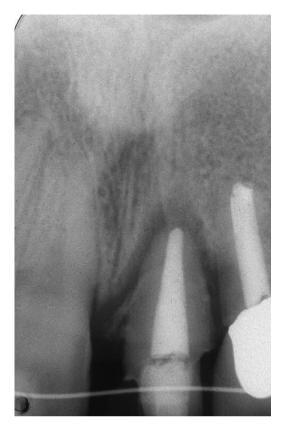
A radiograph taken during the supereruptive process demonstrates coronal repositioning of the alveolar bone between the central and lateral incisors.
